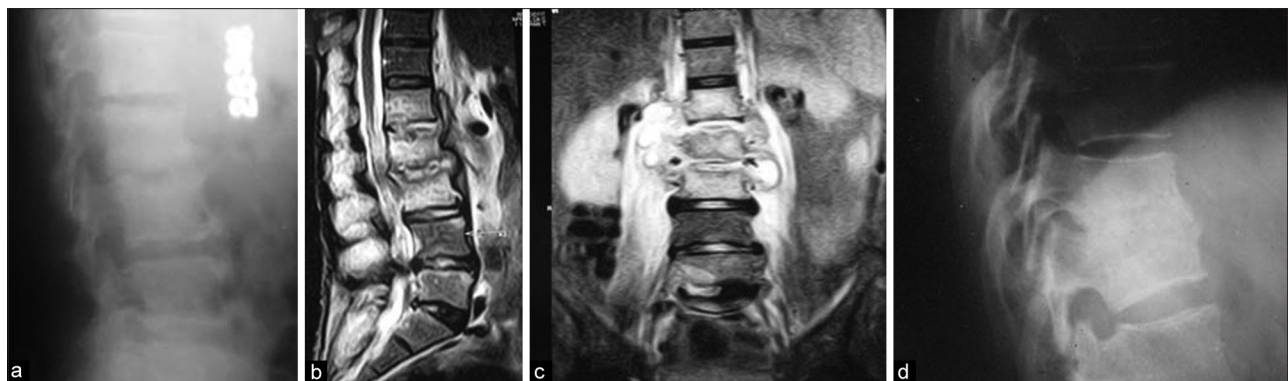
(a) X-ray lumbar spine lateral view at presentation showing narrowing of L3/4 disc space with end plate erosion. (b and c) T2W MRI mid sagittal and coronal views showing hyperintense/contrast enhancement suggestive of edema/inflammation involving bodies of L1, L2, L3 with end plate irregularities and disc space narrowing at L2-L3. There is hyper intense/contrast enhanced para vertebral abscess/soft tissue component extending from L1 to L3 level. The para spinal muscles are edematous (d) the same patient after 9 months of DOTS showing healing with bony fusion
